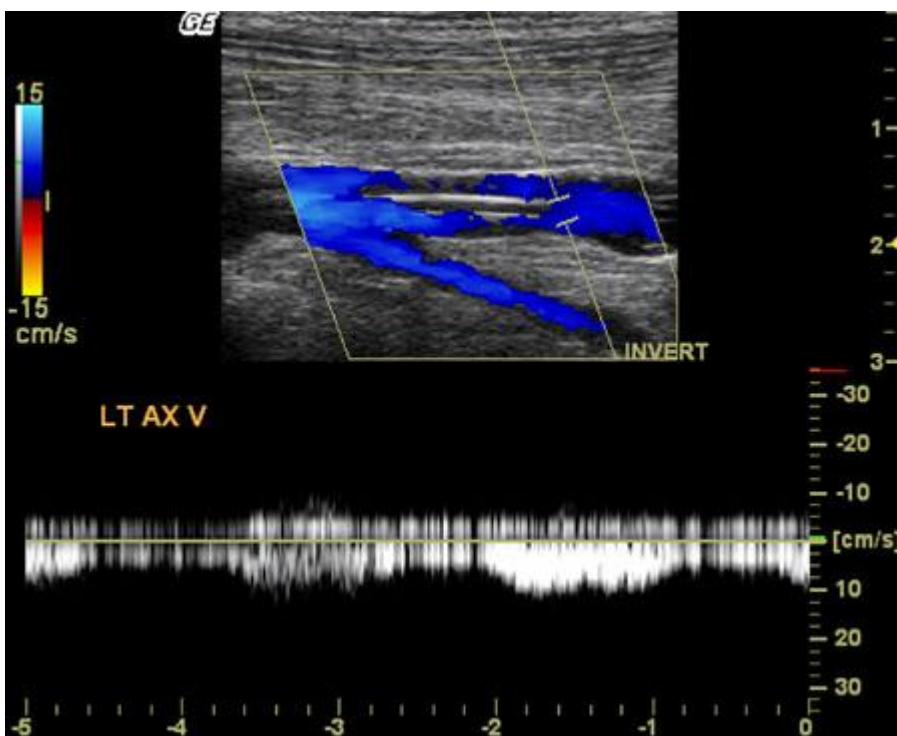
This color Doppler image shows blood flow around the catheter. This is a typical finding since the PICC is normally smaller than the diameter of the vein. Absence of blood flow should be considered as possible evidence of a developing obstructive vein thrombosis. The small size of the cephalic vein
